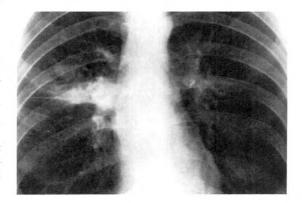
Posteroanterior roentgenogram of the chest showing segmental atelectasis and pneumonic infiltration superimposed on an area of mucoid impaction.
